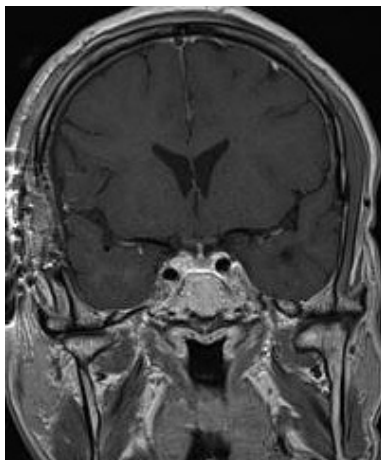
Postoperative magnetic resonance imaging findings. A postoperative T1-weighted gadolinium-enhanced coronal image shows resection of the tumor adjacent to the pituitary stalk. The pituitary stalk remains intact.
